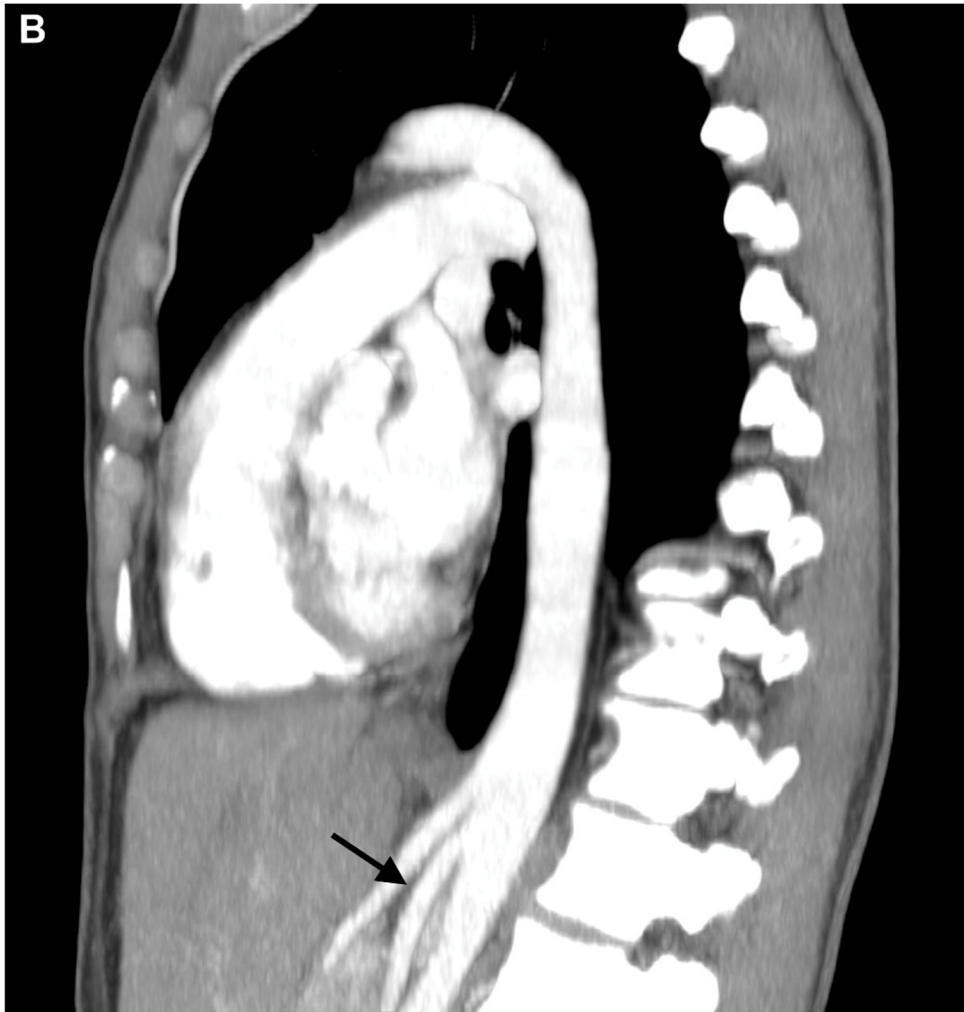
Sagittal computed tomography. The aortomesenteric angle is reduced to 14° (black arrow).
